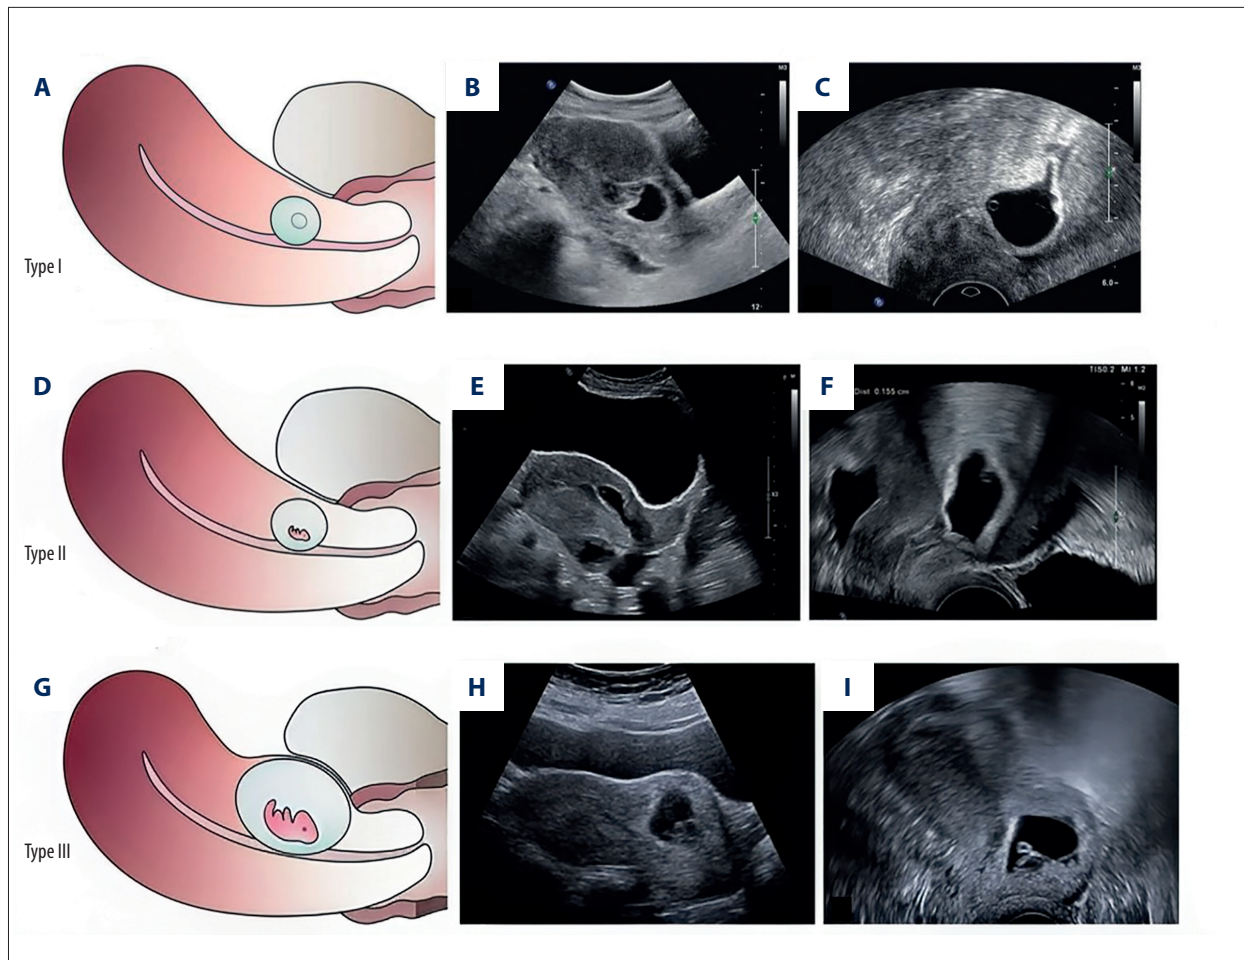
(A-I) Representative transvaginal ultrasound images of cesarean scar pregnancy (CSP) subtypes. Type I CSP: Gestational sac protruding into the uterine cavity, with a thick myometrial layer between the sac and the bladder. Type II CSP: Gestational sac embedded in the myometrium without crossing the serosal contour. Type III CSP: Gestational sac partially extending beyond the outer contour of the uterus, indicating extrapelvic extension.
